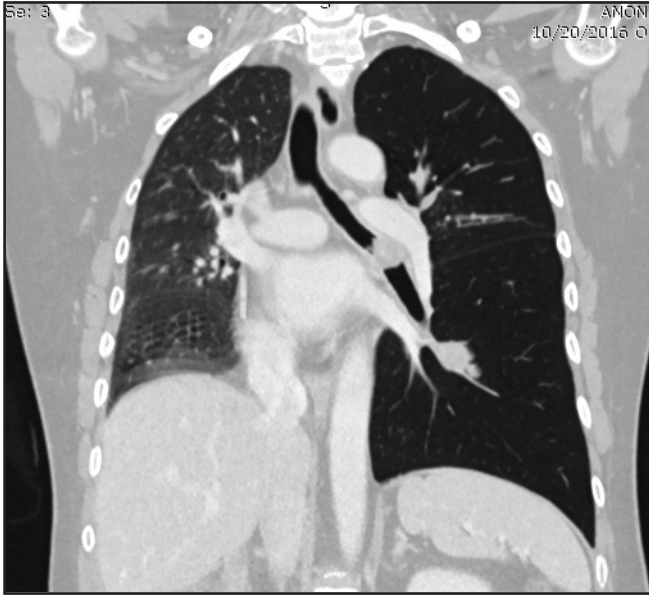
Contrast enhanced computed tomography of thorax showed a lingular mass with endobronchial extension into the left main bronchus (LMB) causing obliteration of the airway with hyperinflation of left lung.
